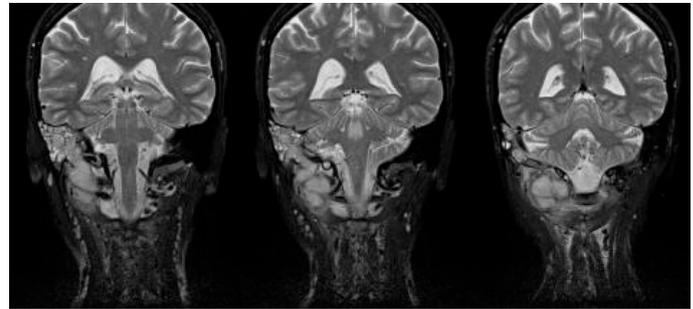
MRI – extensive, heterogeneous infiltration showing signs of abscess penetrating to the cranial base and paravertebrally at C2 level on the right side.
